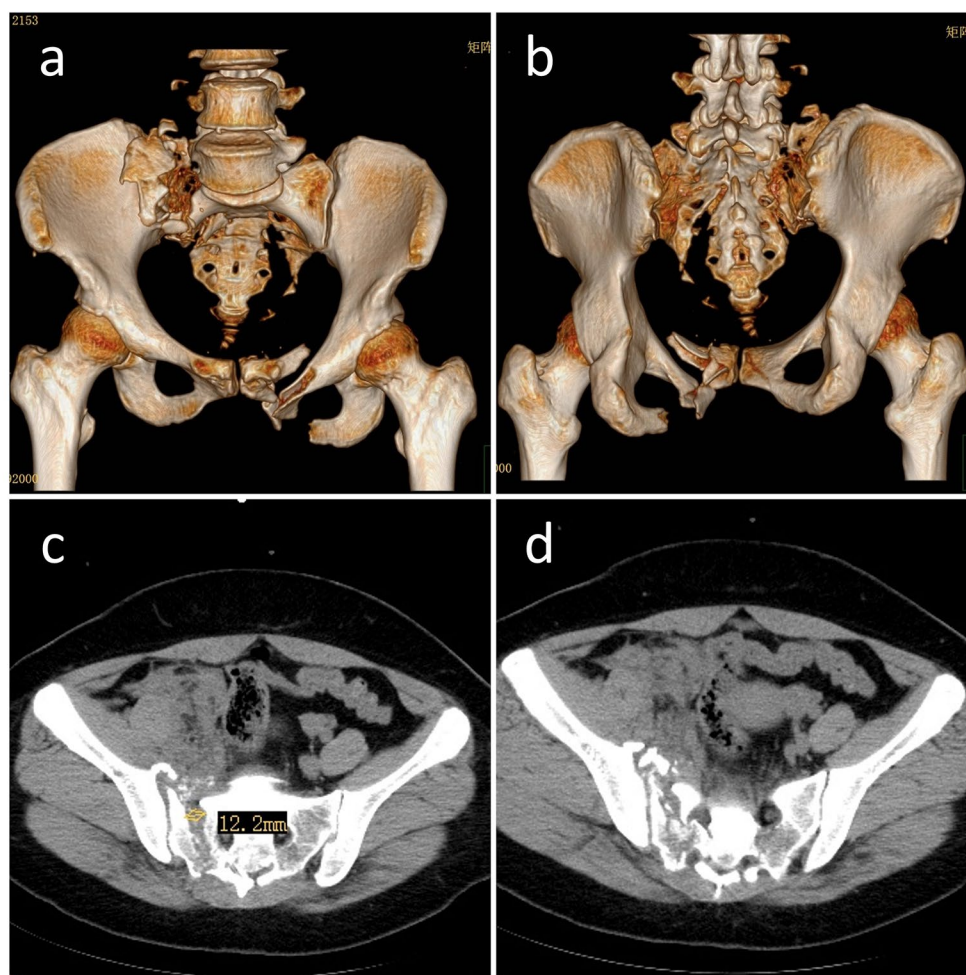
Case 1: Preoperative three-dimensional CT of a 40-year-old female patient showing Tile type C2 pelvic fracture (a–d)
